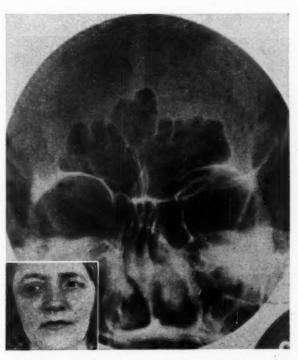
(Pfeiffer). Case 8. Meningioma of sphenoid crest without apparent hyperostosis. Roentgenogram showing the effect of increased pressure in the right orbit. Note the increased concavity and thinness of the walls, the increased capacity of the cavity, and the enlargement of the orbital entrance.
